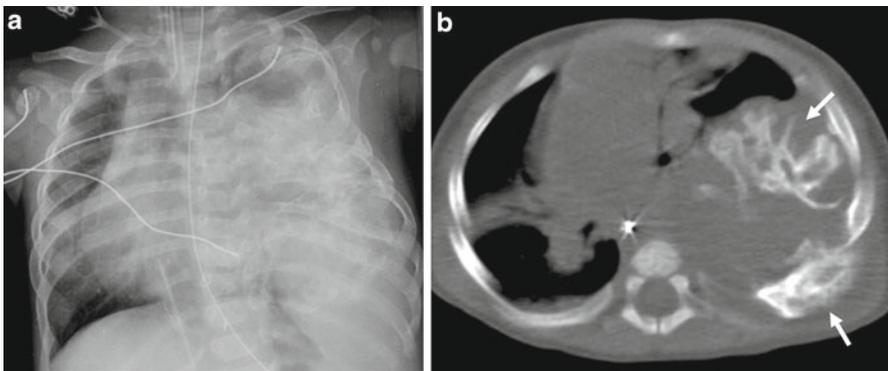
Chest wall deformity. Supine chest radiograph (a) and axial CT image (b) in a neonate with large left mesenchymal hamartoma involving multiple ribs and causing significant mediastinal shift. CT delineates degree of osseous involvement and soft tissue components (*arrows*)
